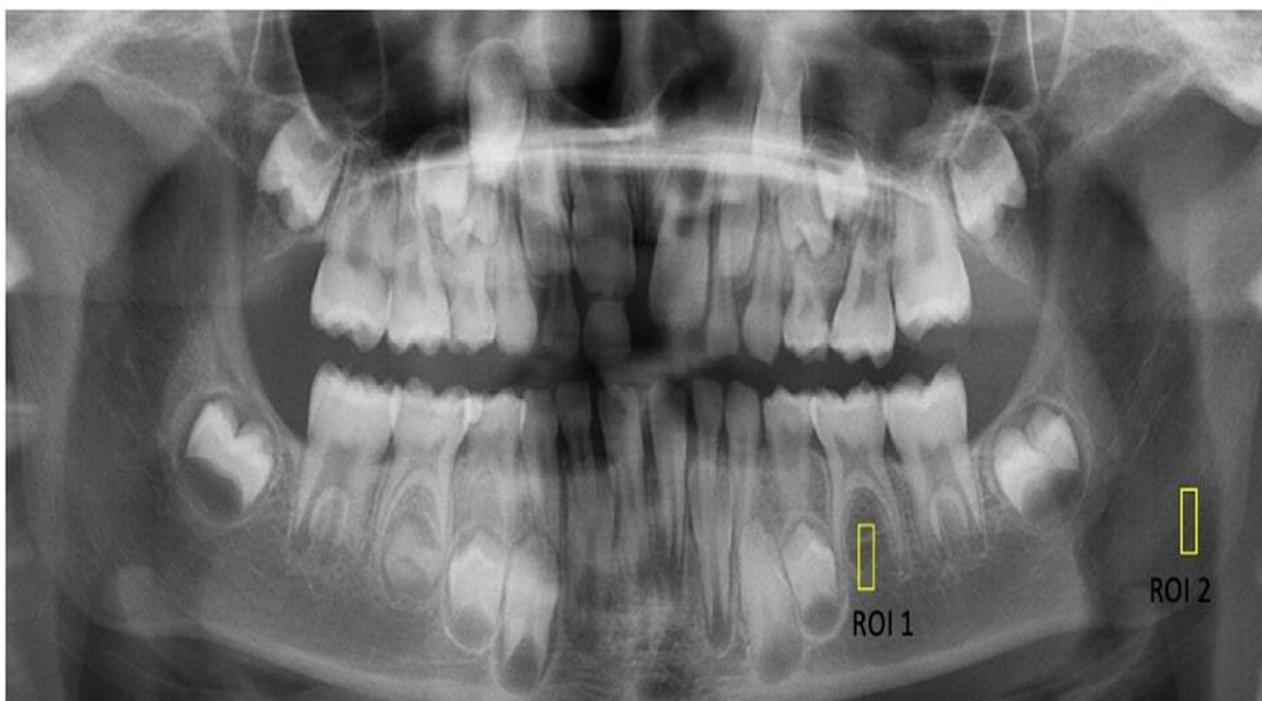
Selection of ROI 1 and ROI 2 on a panoramic radiograph. ROI: region of interest.
